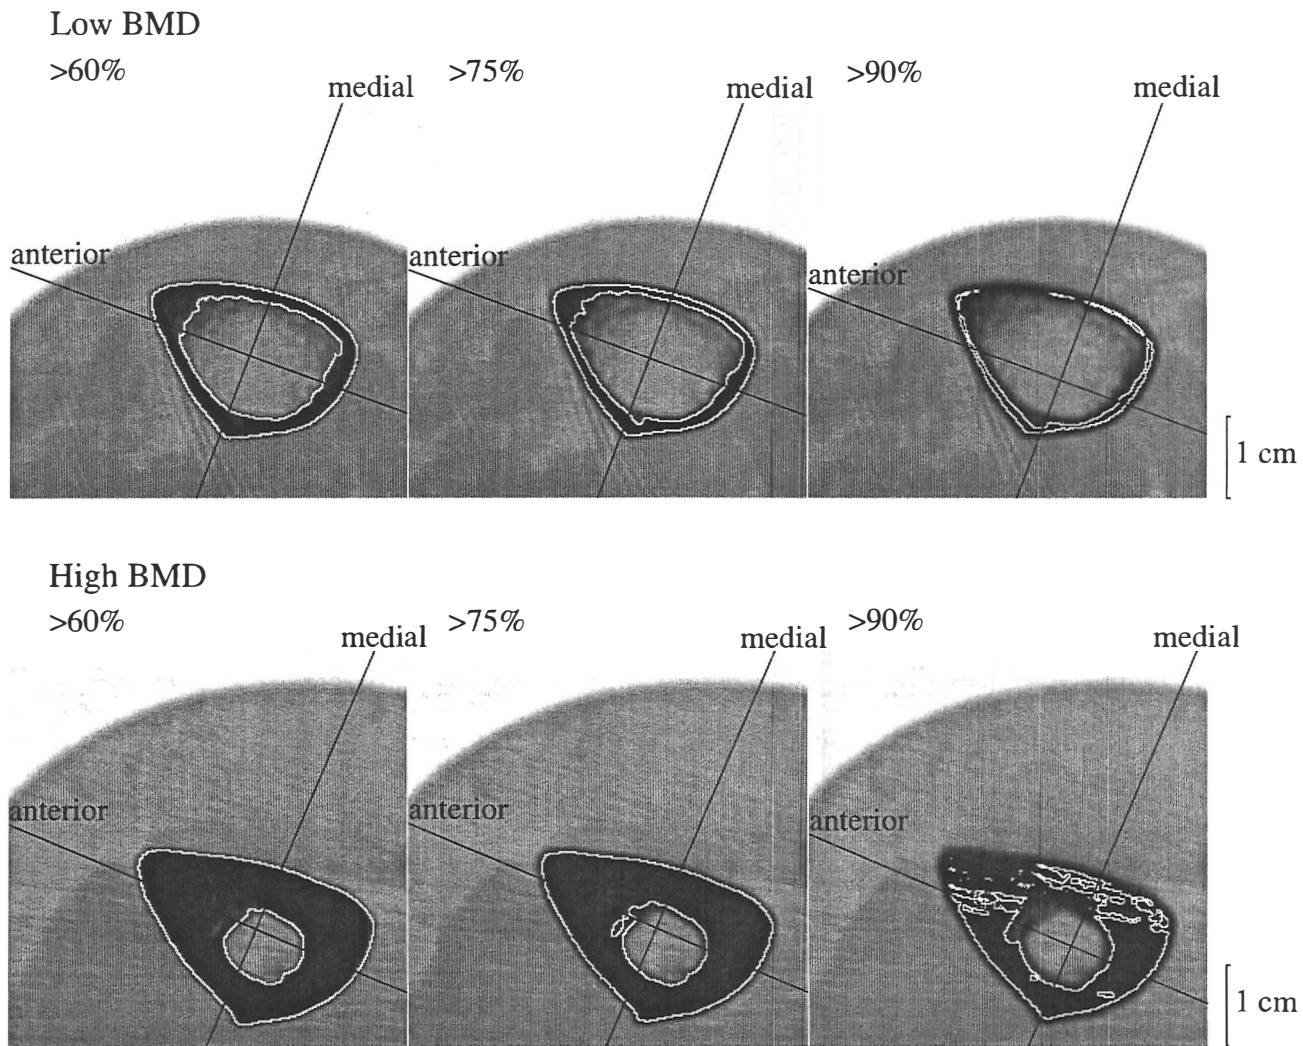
Example of bone mass distribution around center axis for cross-sectional areas representing different density levels (percentages of maximum value of BMD) in the CT scan. Low BMD woman (above) and high BMD woman (below). Cross section through the middle shaft of the right leg. Sectioned surfaces viewed from distal.
